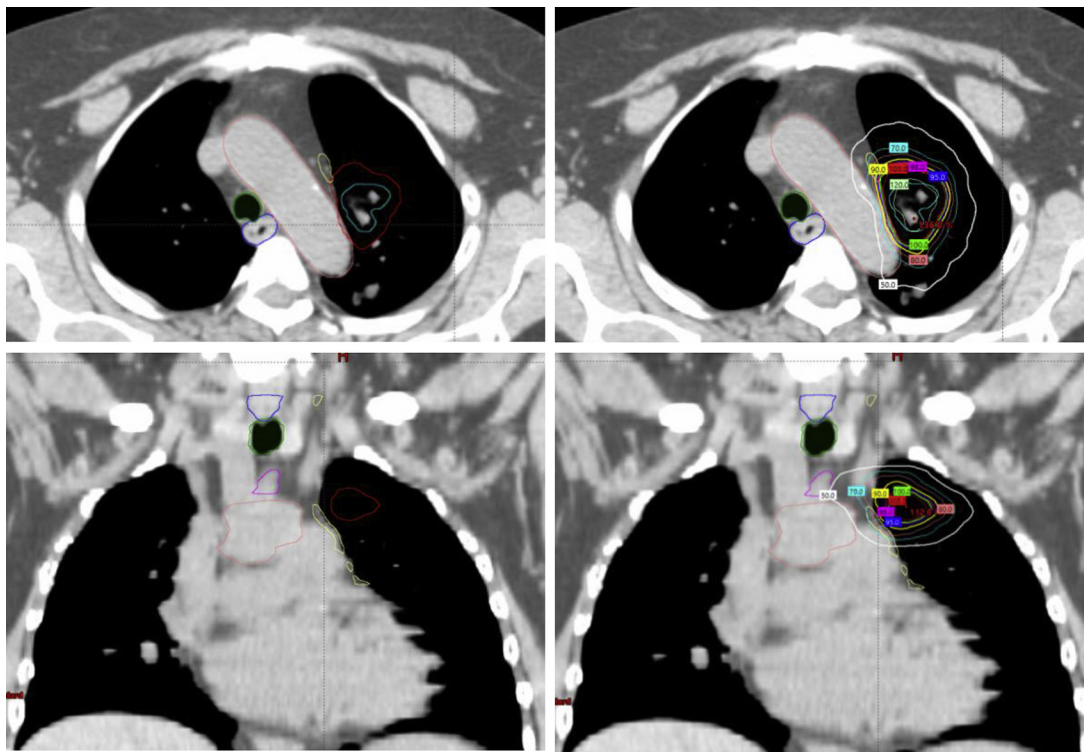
Case 2. PTV delineated with segmentation of expected path of PHN (yellow) (left column, upper and lower panels); dosimetric distribution of the treatment plan targeting left upper lobe tumor treated with 52.5 Gy in five fractions (right column, upper and lower panels). Isodose curves displayed as a percentage of prescription dose. Windowing optimized for mediastinal structures underrepresents the true borders of the primary tumor. PHN, phrenic nerve; PTV; planning computed tomography with target volume.
